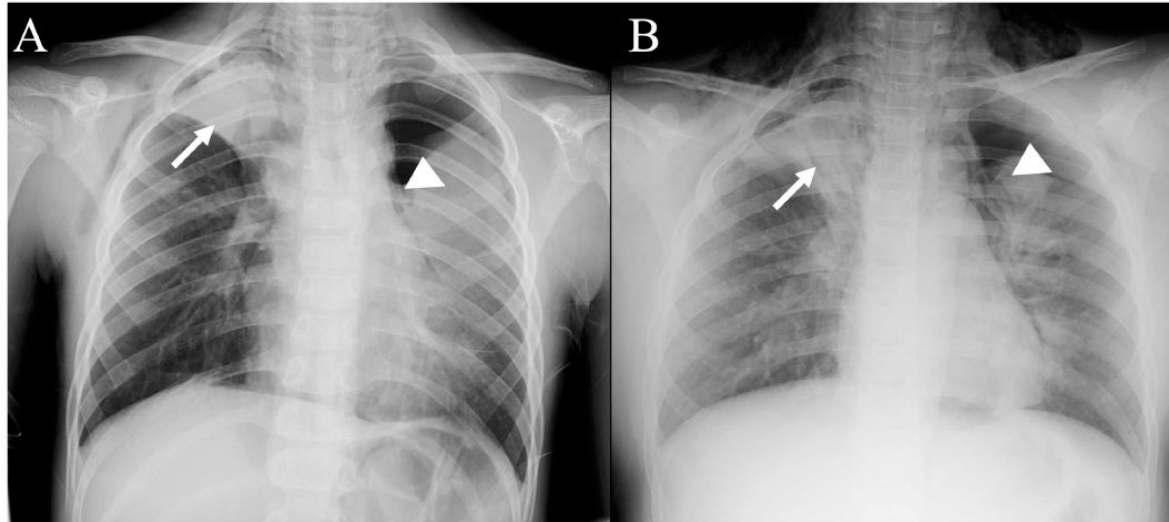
Chest radiographs. Chest radiographs of two pediatric patients with influenza infection in different seasons. (A) Case 1 (6-year-old with asthma). (B) Case 2 (11-year-old without history of asthma) demonstrates marked right upper lobe atelectasis (arrows). A contralateral left-sided pneumothorax is also visible (arrowheads). Diffuse haziness involving both lung fields is also observed, suggestive of diffuse lung involvement.
